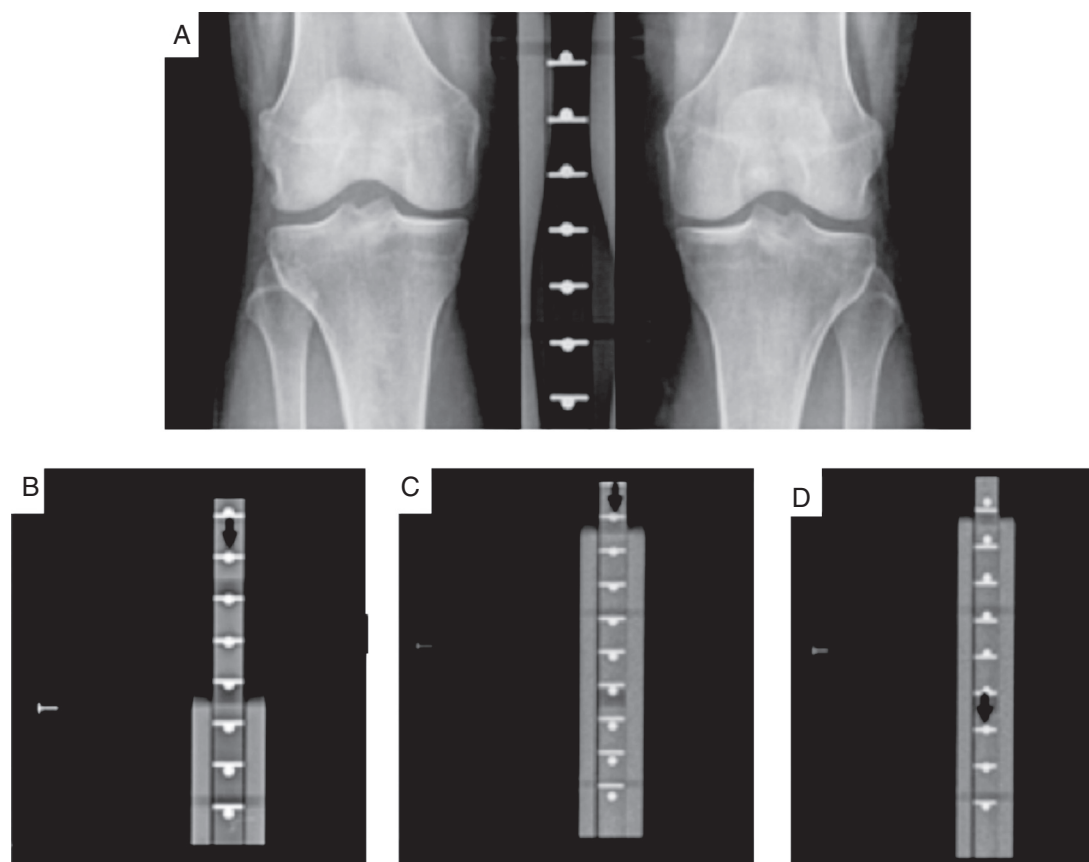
Distribution of radiopaque markers in the novel positioning device. (A) X-ray beam tangential to articular knee space at 10° caudal angulation; (B) X-ray beam 2 cm above articular knee space at 10° caudal angulation; (C) X-ray beam tangential to articular knee space at 12° caudal angulation; (D) X-ray beam tangential to articular knee space at 8° caudal angulation. In B–D, the coincidence of a pair of radiopaque markers (arrow) away from the level of the articular knee space (represented by ‘t’) is indicative of inadequate angulation and/or centralization of the X-ray beam.
